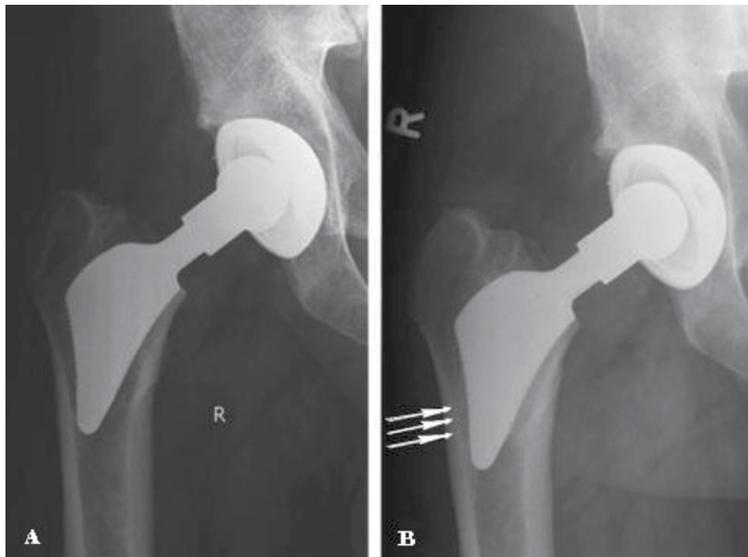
Undersized Proxima™ short-stem in severe varus position (a) immediate postoperative radiograph (b) radiograph 4 year post-op. Even though the long neck is biomechanically disadvantageous, after 4 years the position of the stem is the same. Strengthening of the trabecular structure against the lateral aspect of the stem (arrows) is stimulated by proximal loading (Wolf’s law).
